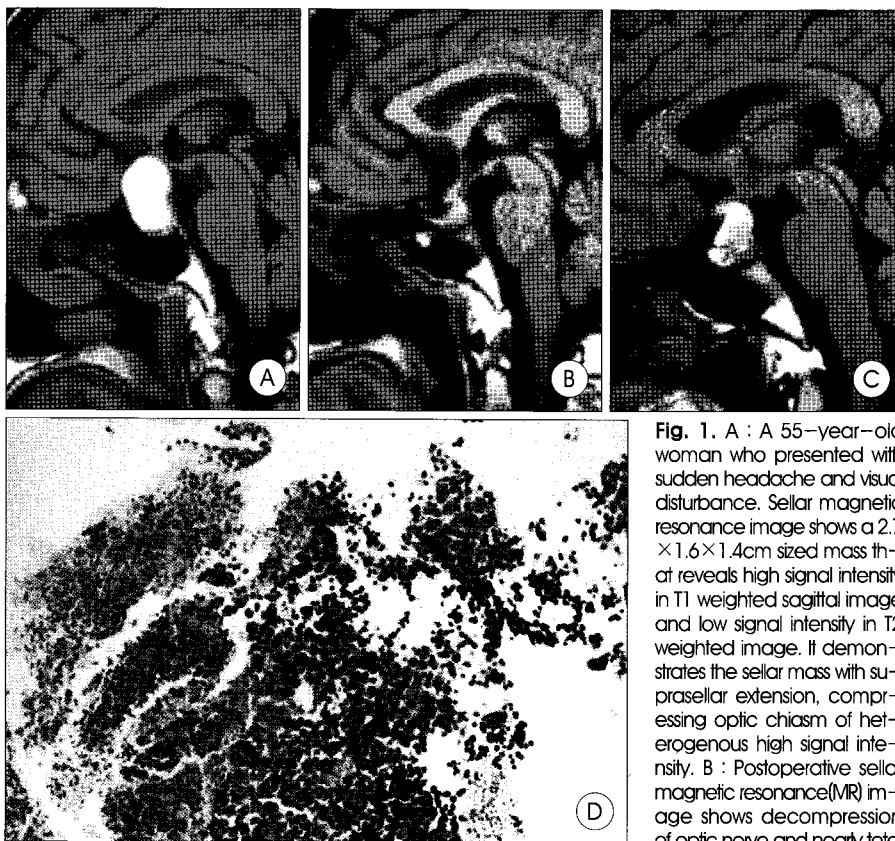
A : A 55-year-old woman who presented with sudden headache and visual disturbance. Sellar magnetic resonance image shows a 2.7×1.6×1.4cm sized mass that reveals high signal intensity in T1 weighted sagittal image and low signal intensity in T2 weighted image. It demonstrates the sellar mass with suprasellar extension, compressing optic chiasm of heterogeneous high signal intensity. B : Postoperative sellar magnetic resonance(MR) image shows decompression of optic nerve and nearly total
